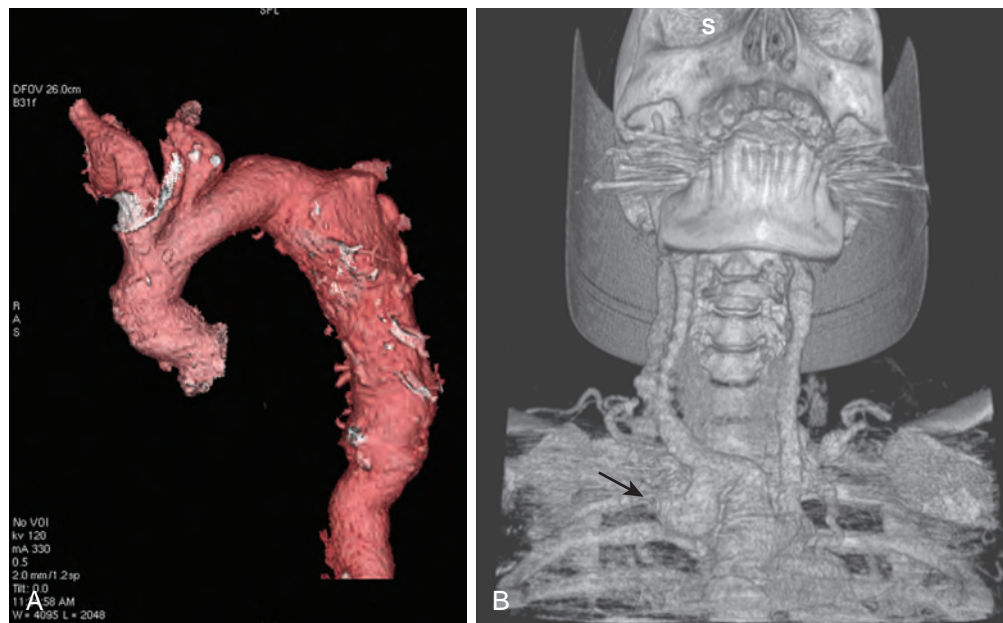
Three-dimensional reconstruction from a computed tomographic angiogram of the aorta (A) and aortic arch branch vessels (B) from a patient with Takayasu arteritis. The reconstructions demonstrated aneurysmal dilation of the descending thoracic aorta, proximal innominate artery, and both subclavian arteries. The left and right (arrow) subclavian arteries were occluded distal to the aneurysm.
